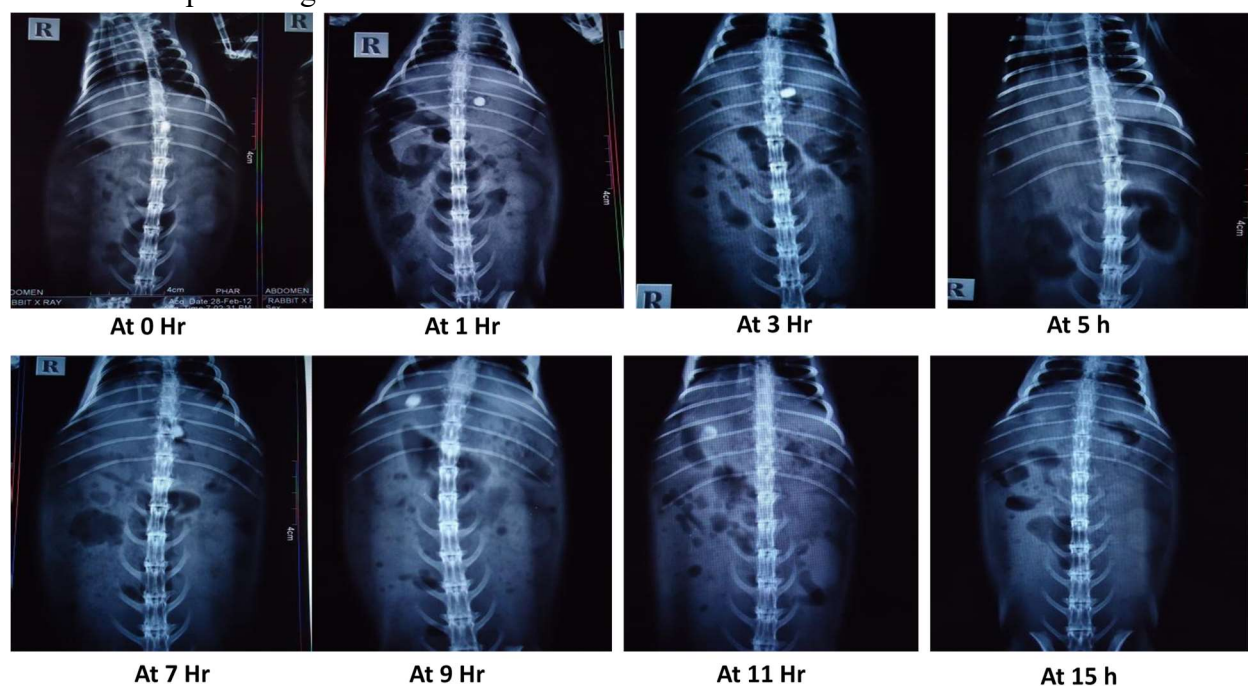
Observations for Roentgenographic study of Budesonide tablets
